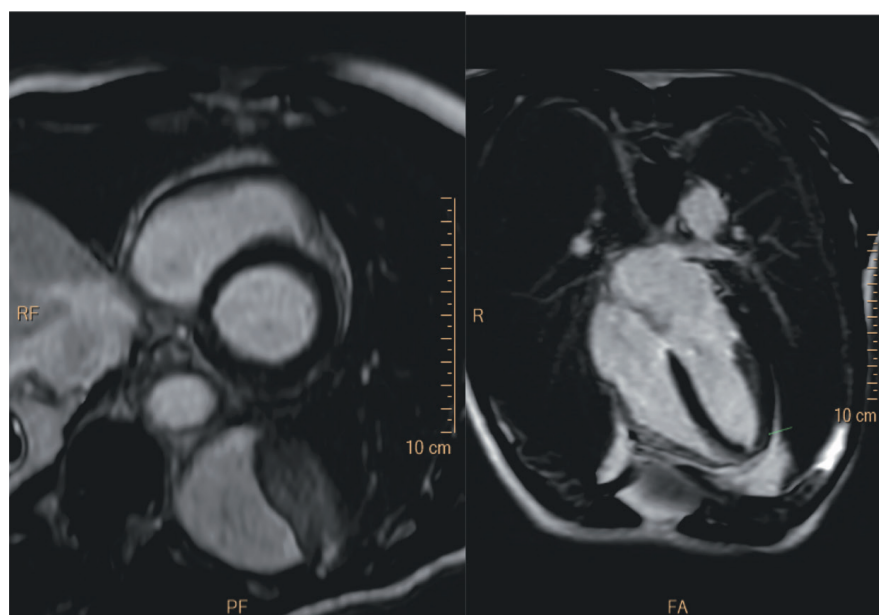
Control cardiac magnetic resonance imaging (at 3 months follow-up) showing normalised myocardial signal in basal and mid thirds of the heart, persistent delayed myocardial enhancement of the gadolinium in apical lateral segment.
